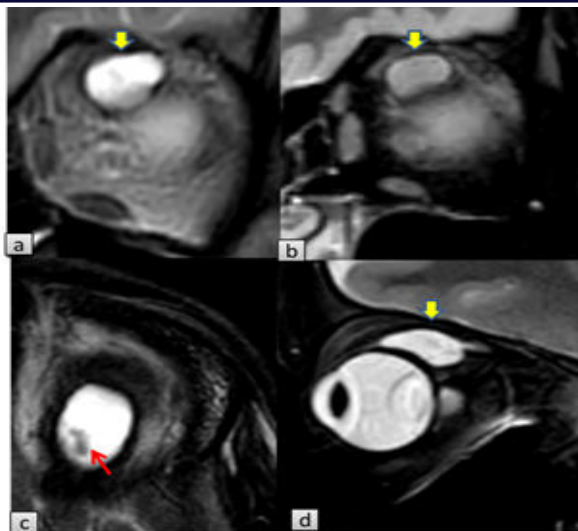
MRI Orbit: Coronal sections: T2 fat suppressed (a) and STIR (b) sequences show presence of cystic lesion (yellow arrow) of size ~9x6x14mm seen involving left superior rectus muscle which is hyperintense on T2 WI. Rest extra-ocular muscles are normal. Axial (c) T2 weighted images showing hyperintense lesion in the superior rectus with eccentric hypointense focus (red arrow) likely representing scolex. Sagittal (d) T2 weighted images showing lesion along the superior rectus muscle.
